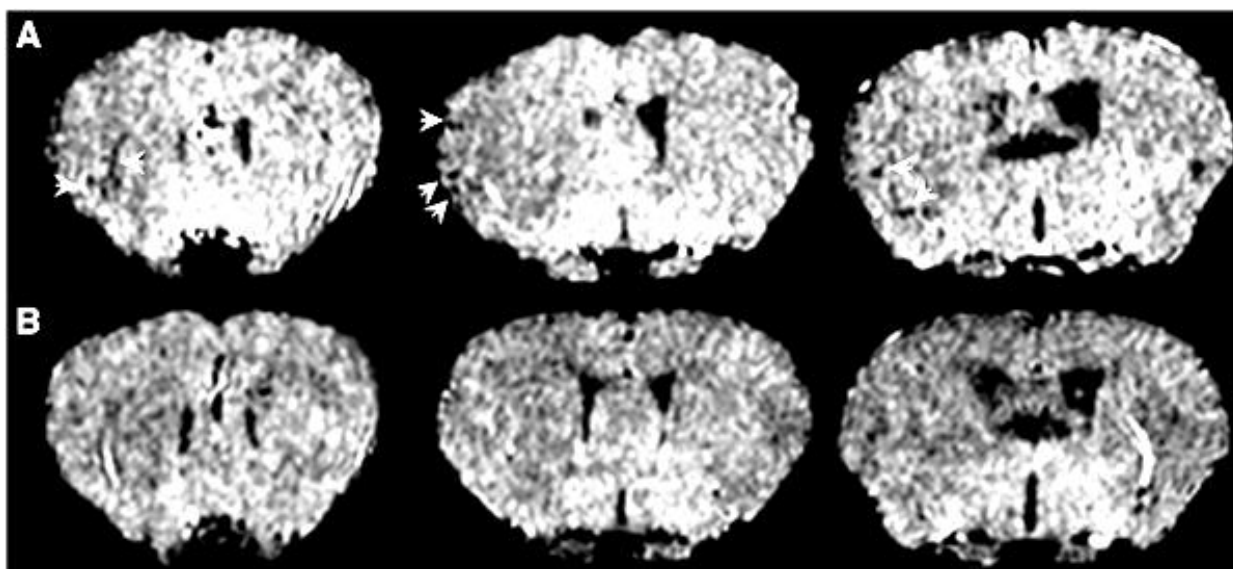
MRI of VCAM-MPIO binding in ischemic cerebral hemispheres
